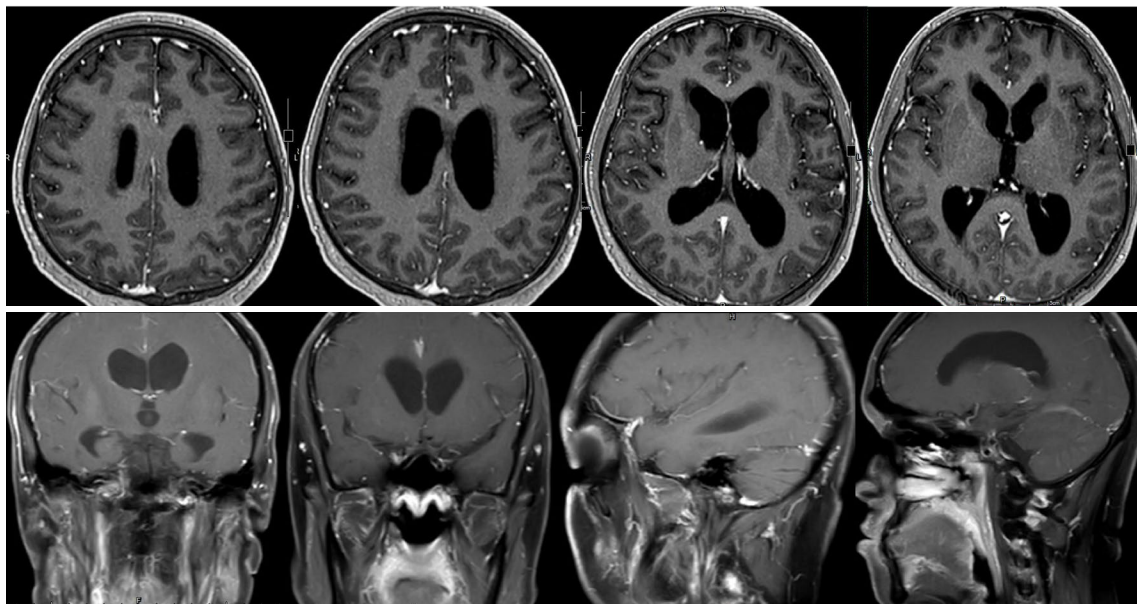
MRI of head at one month after whole brain radiotherapy combined with capecitabine (T1 weighted contrast enhancement images).
